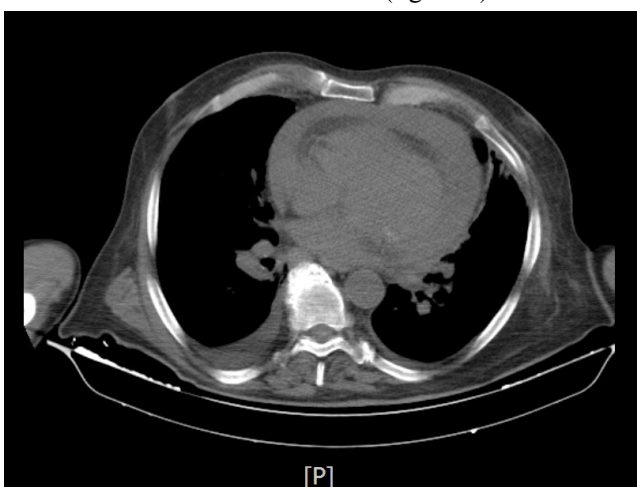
The second non-contrast CT scan of the patient.
